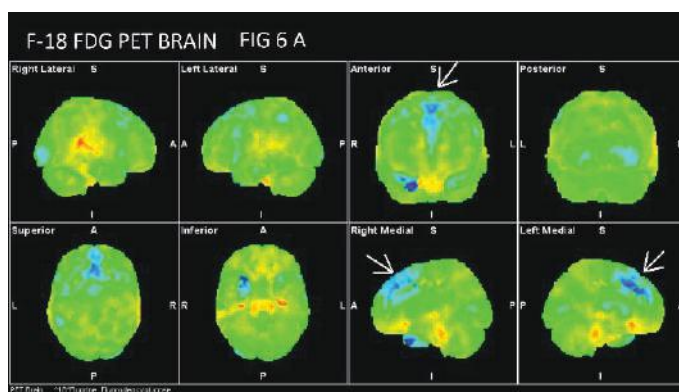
F-18 FDG PET scan (fig. 6a and 6b) findings are suggestive of mild hypometabolism in bilateral basal ganglia, bilateral frontal cortices in the midline including anterior cingulate and bilateral parieto-temporal lobes. F-18 FDOPA scan (fig. 6c) findings are suggestive of symmetrically reduced dopamine synthesis
